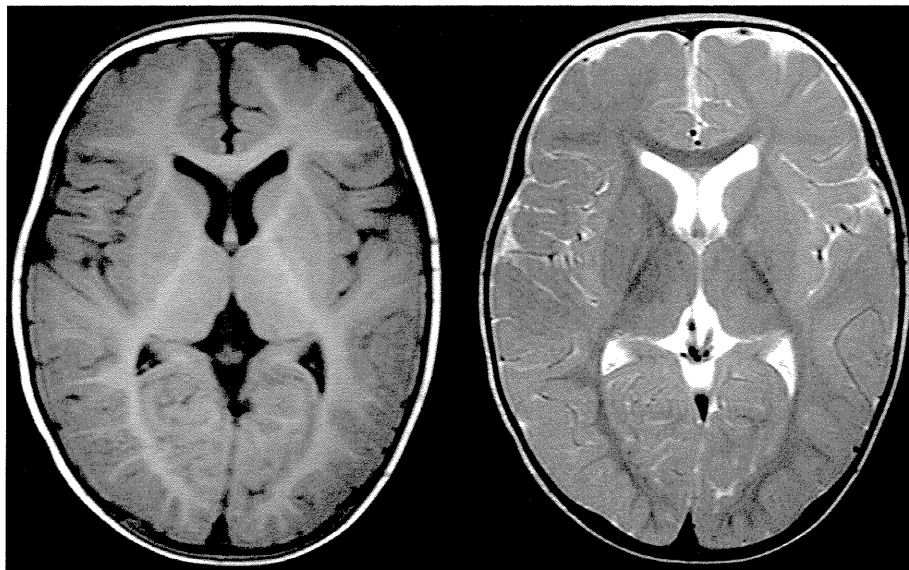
Brain MRI findings in a normally developing 12-month-old boy. T1 – (left) and T2 – (right) weighted axial images the slice matched with that reported by Azzolini et al. The subcortical regions are enough high and low in T1- and T2-weighted images, respectively. This patient was examined for the aim of the disease screening for epilepsy and the results came out as normal.
